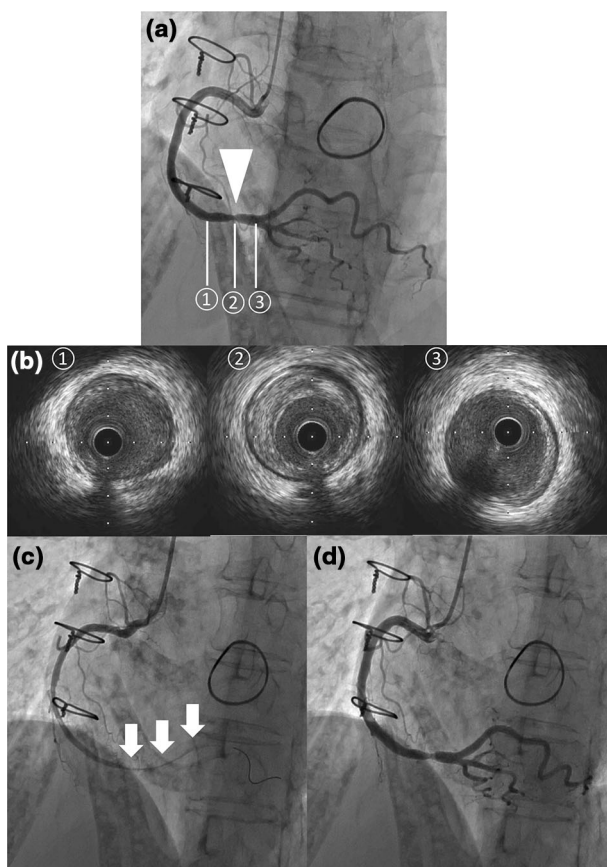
Angiography revealed 50% stenosis in the mid portion of the right coronary artery (white arrow head) (a). Intravascular ultrasound (IVUS) showed fibrous plaque with no evidence of thrombus or plaque rupture (b). When 15 μ g of ergonovine was infused into the right coronary artery, a coronary occlusion occurred at the same site of the stenosis (white arrow) with recurrent angina and ST elevation in leads II, III, and aVF (c). After intracoronary nitroglycerin injection, the RCA occlusion disappeared (d)
